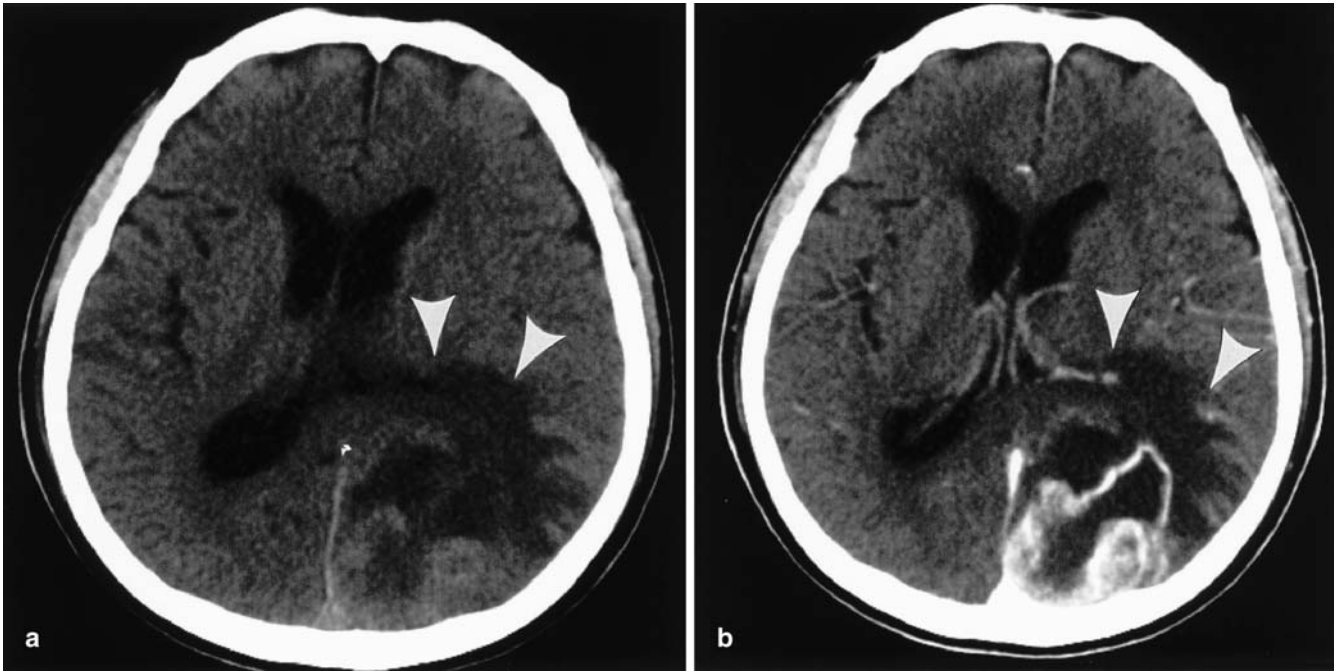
Brain metastasis. a Unenhanced CT scan shows extensive edema (*arrowheads*) in the left parieto-occipital lobe with mass effect. b Contrast-enhanced CT scan shows a rim-enhancing mass in the left parieto-occipital lobe
